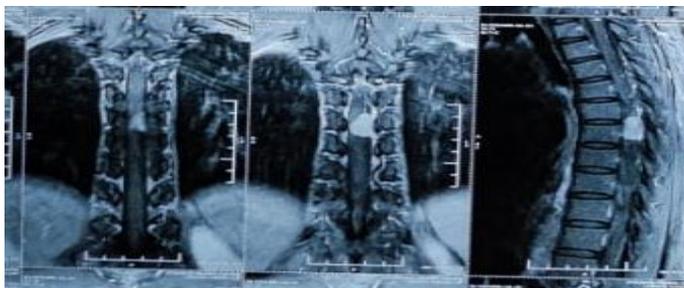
MRI showing a well-defined round to oval solid homogeneously enhancing extra medullary intra Dural lesion in dorsal spinal canal posterior to D6-D7 disc and superior half of D7 vertebral body
